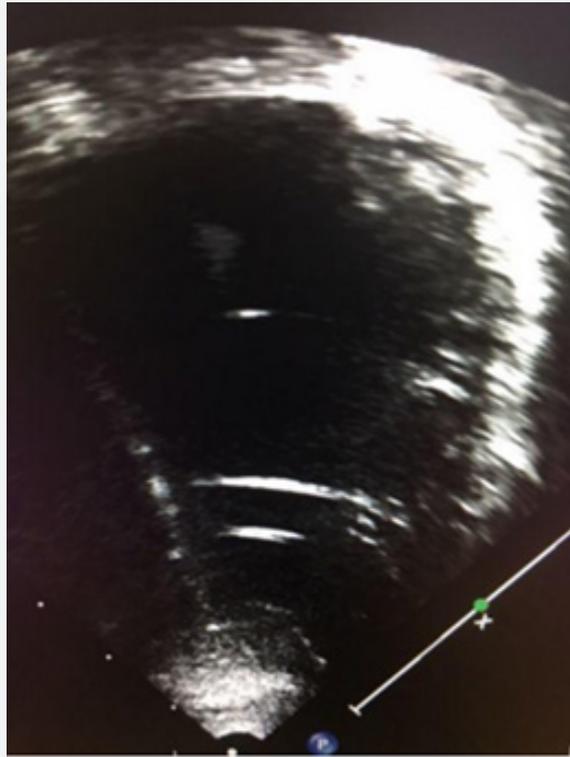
Echocardiographic image demonstrating false tendons in the left ventricle.
